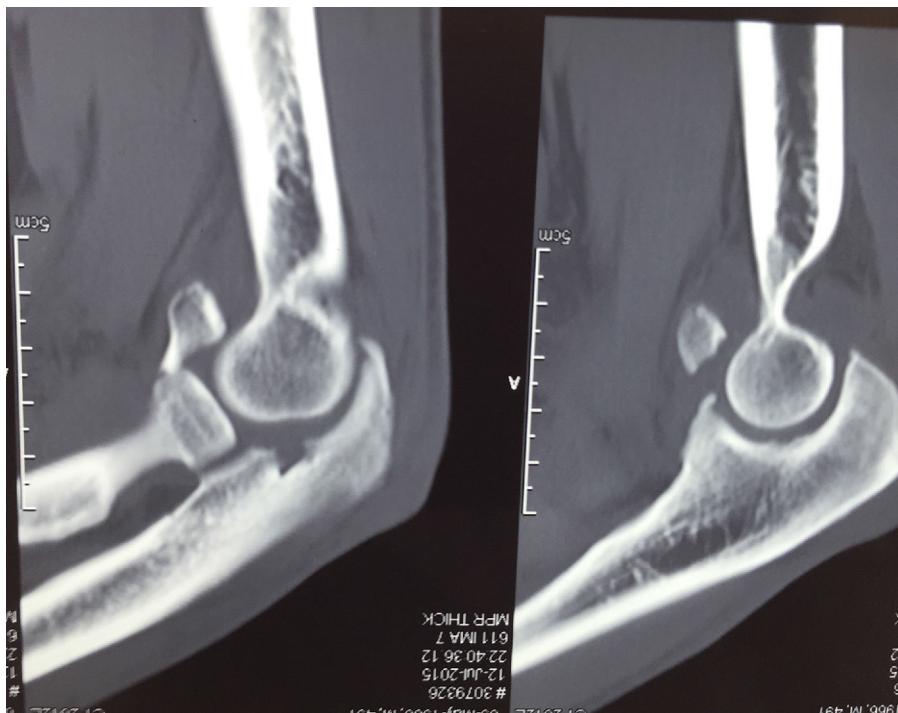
Sagittal plane CT scan showing the radial head fracture and anterior displacement of the fragment.
